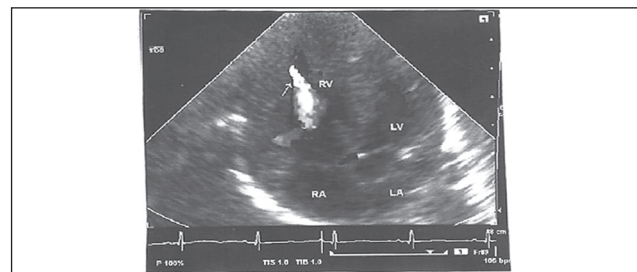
Color Doppler echocardiograph in apical four-chamber view showing turbulent jet coming from RV apex to RV cavity.
